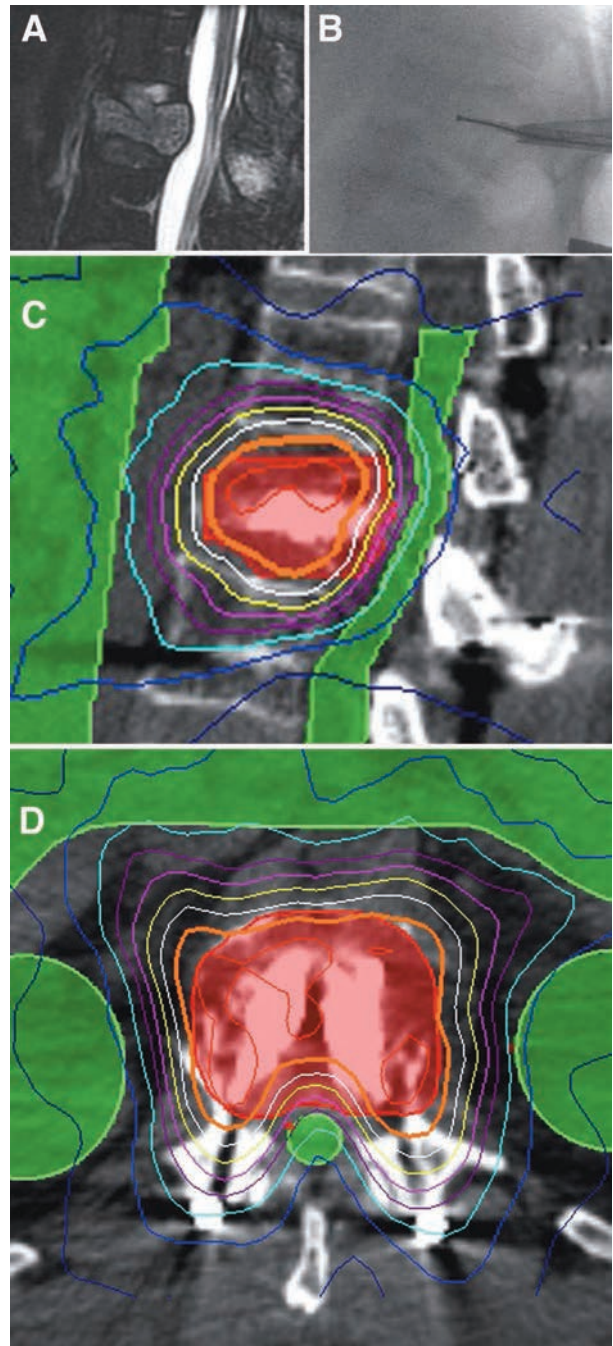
Images obtained in a 74-year-old man with a symptomatic L-1 thyroid metastasis. A: Sagittal MR image showing the tumor. Note the degree of spinal canal compromise. B: Under fluoroscopic guidance, the device is inserted through an 8-gauge working channel and advanced in multiple directions to remove tumor tissue from within the vertebral body. C and D: Sagittal (C) and axial (D) projections of the isodose lines of the radiosurgical treatment plan demonstrating PMMA within the vertebral body.
